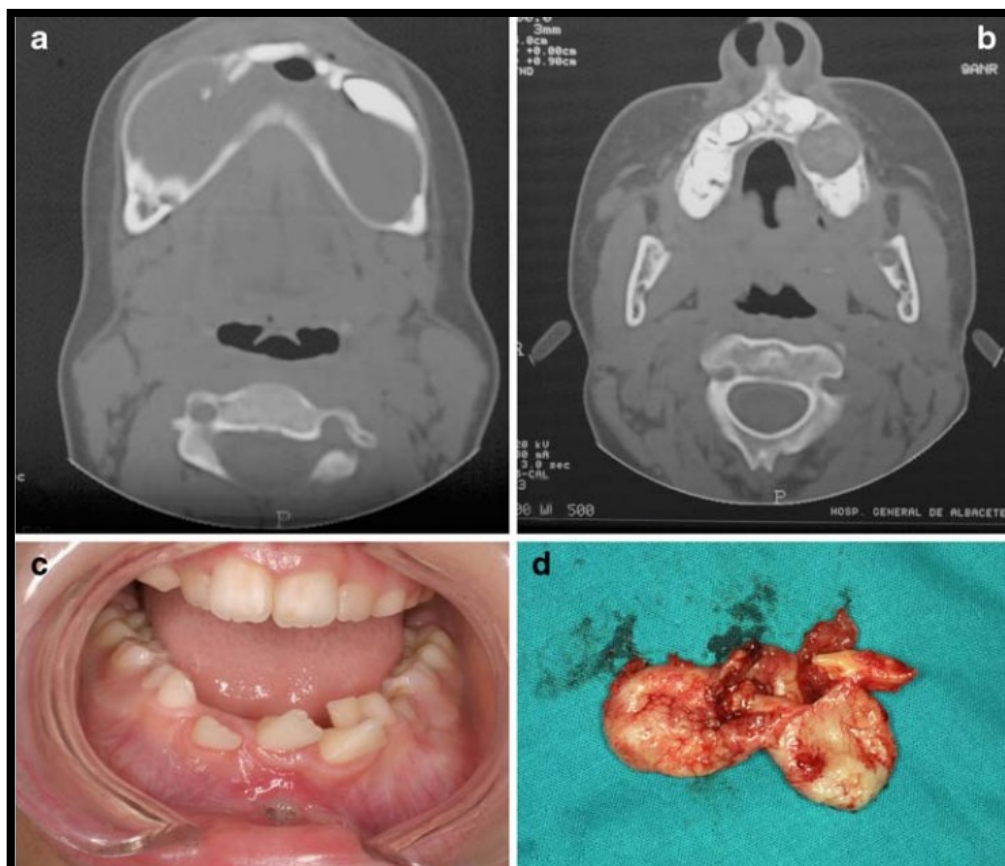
(a) Xray view of the mandibular KOT. (b) Maxillary KOT. (c) An intraoral examination reveals misalignment of the teeth inside the affected area. (d) Surgical resection fragment. Adapted from (García De Marcos et al., 2009).
